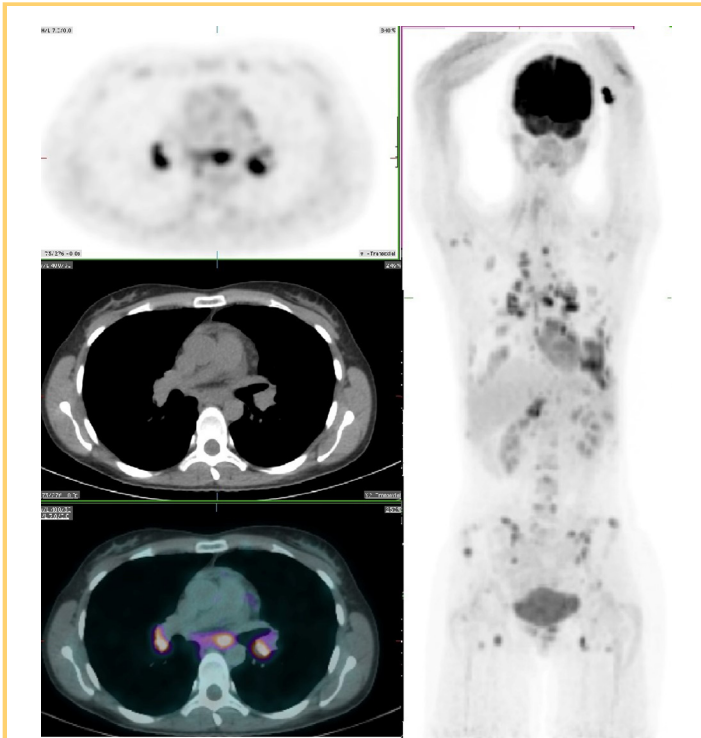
MIP and axial PET, CT, and fused PET/CT images of progress PET/CT 6 months following diagnosis showed widespread FDG-avid uptake in nonenlarged lymph nodes in multiple nodal stations above (hilar lymph nodes arrowheads) and below the diaphragm, spleen, and multiple bones highly suspicious of recurrent disseminated FDG-avid lymphoma.
